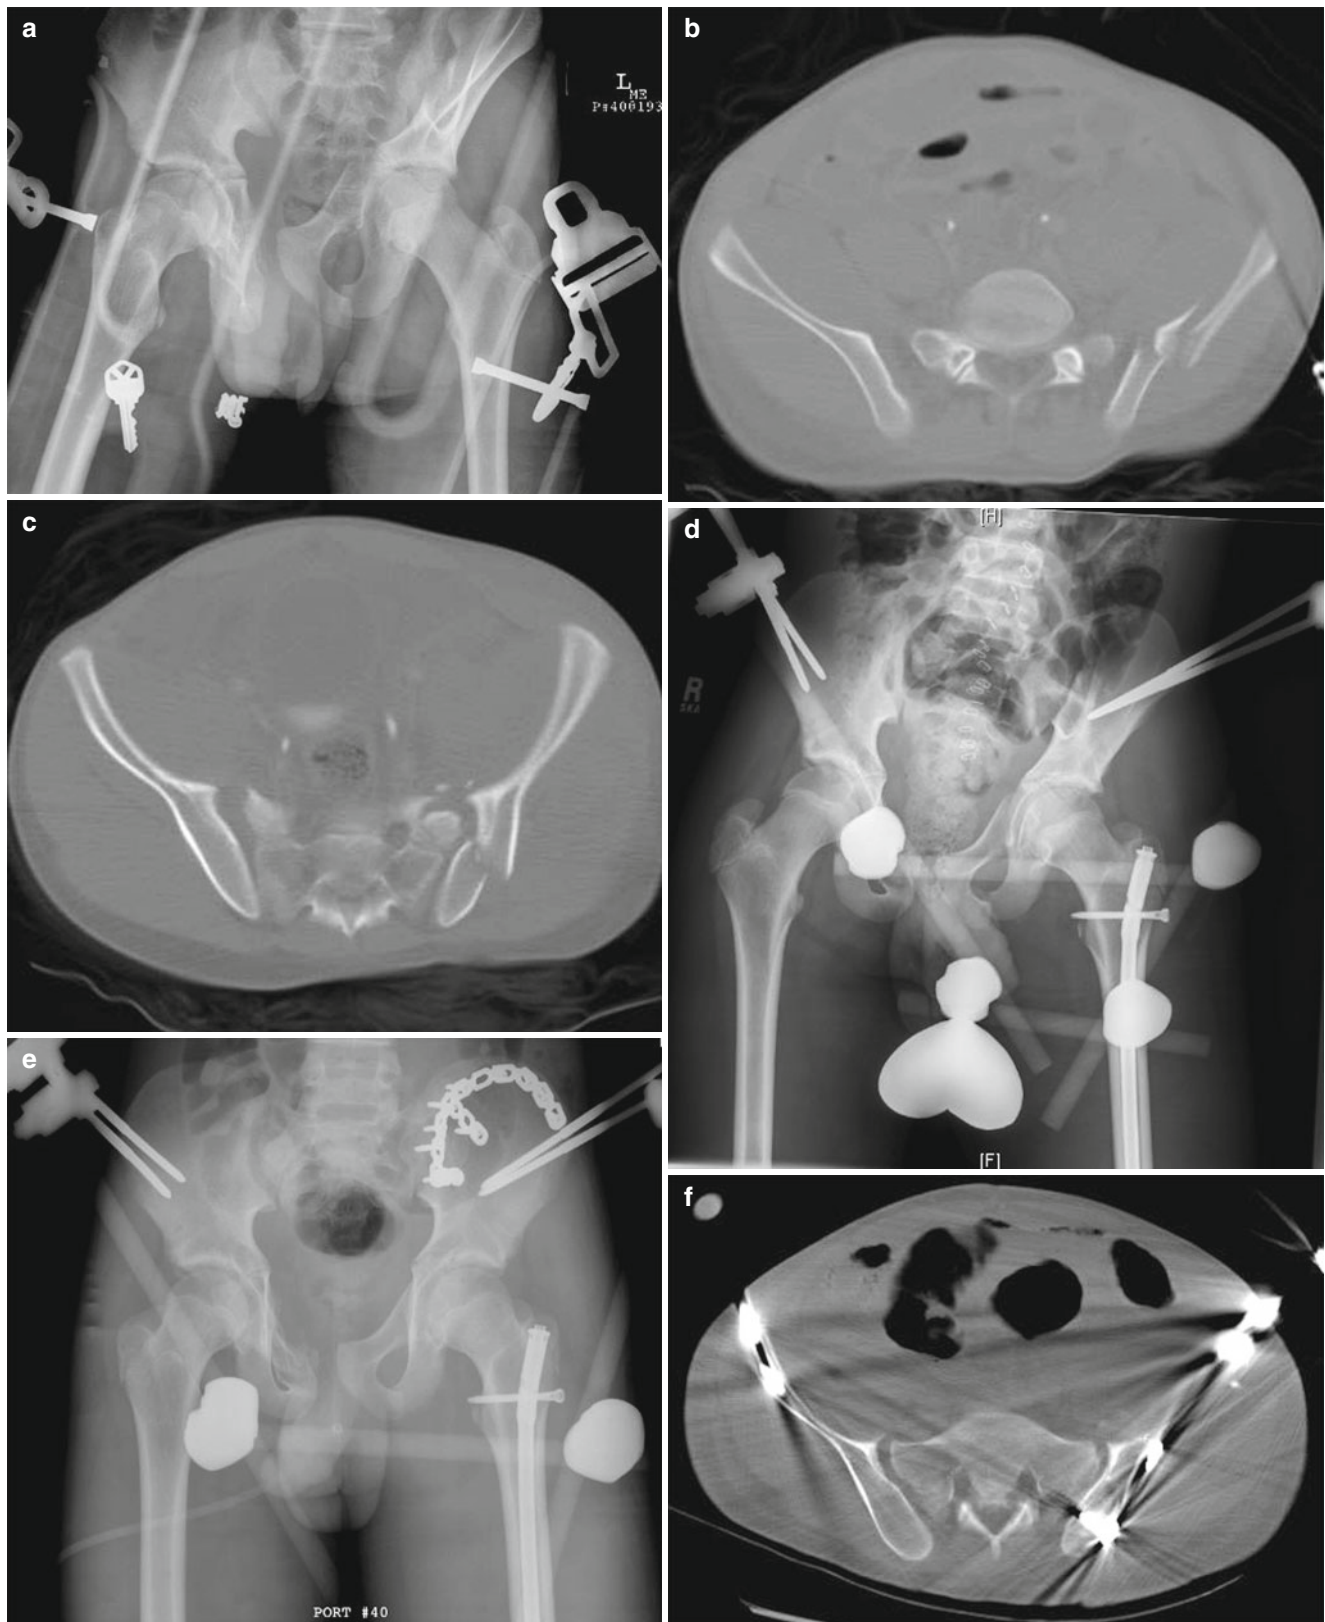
Hemodynamically unstable 15-year-old male multiple trauma victim whose injuries included pelvic and acetabular injuries. (a) Initial injury AP pelvic radiograph demonstrating fracture dislocation of left sacroiliac joint as well as left ischial and acetabular fractures. (b) Computed tomography image demonstrating comminuted fracture of left ilium. (c) Computed tomography image demonstrating left sacroiliac joint involvement – this may be referred to as a pediatric
